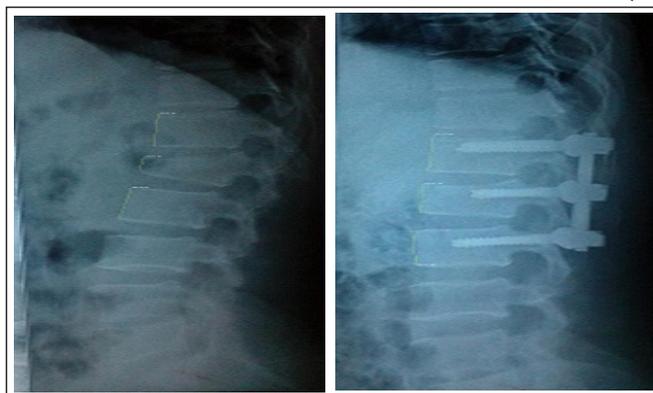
Radiographic imaging demonstrating measurement of anterior vertebral body height
